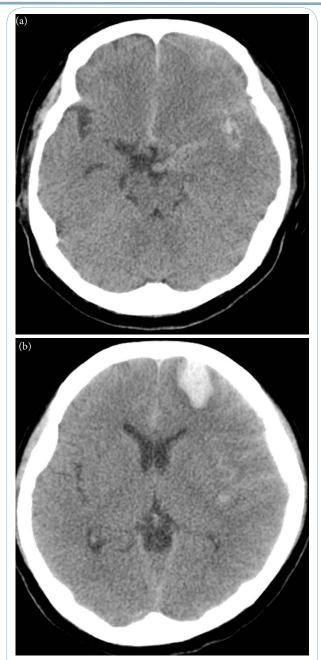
Brain computed tomography (a, b) in the emergency department demonstrating a left hemisphere cortical hemorrhage and subarachnoid hemorrhage located mainly in the left hemisphere.
